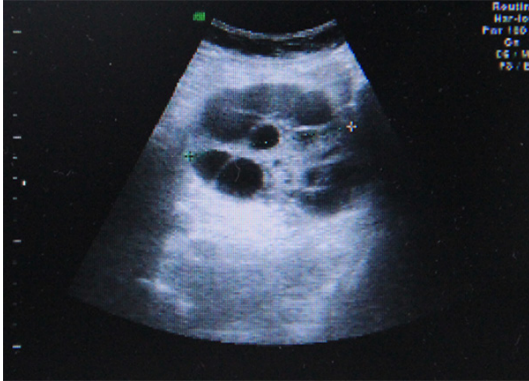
Right ovary in the ultrasoundgram on 16th April, 2014.
